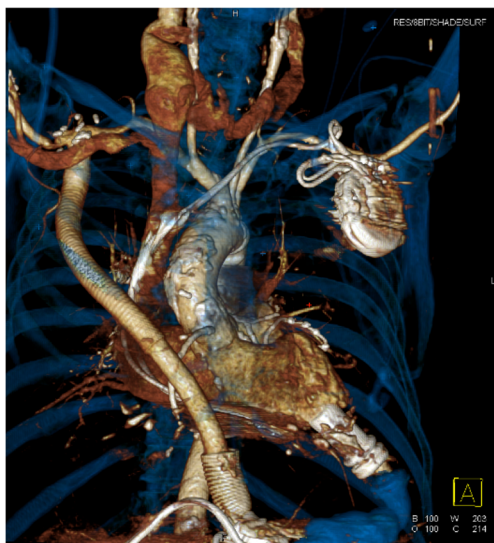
CT scan reconstruction of the outflow graft to the right subclavian artery
